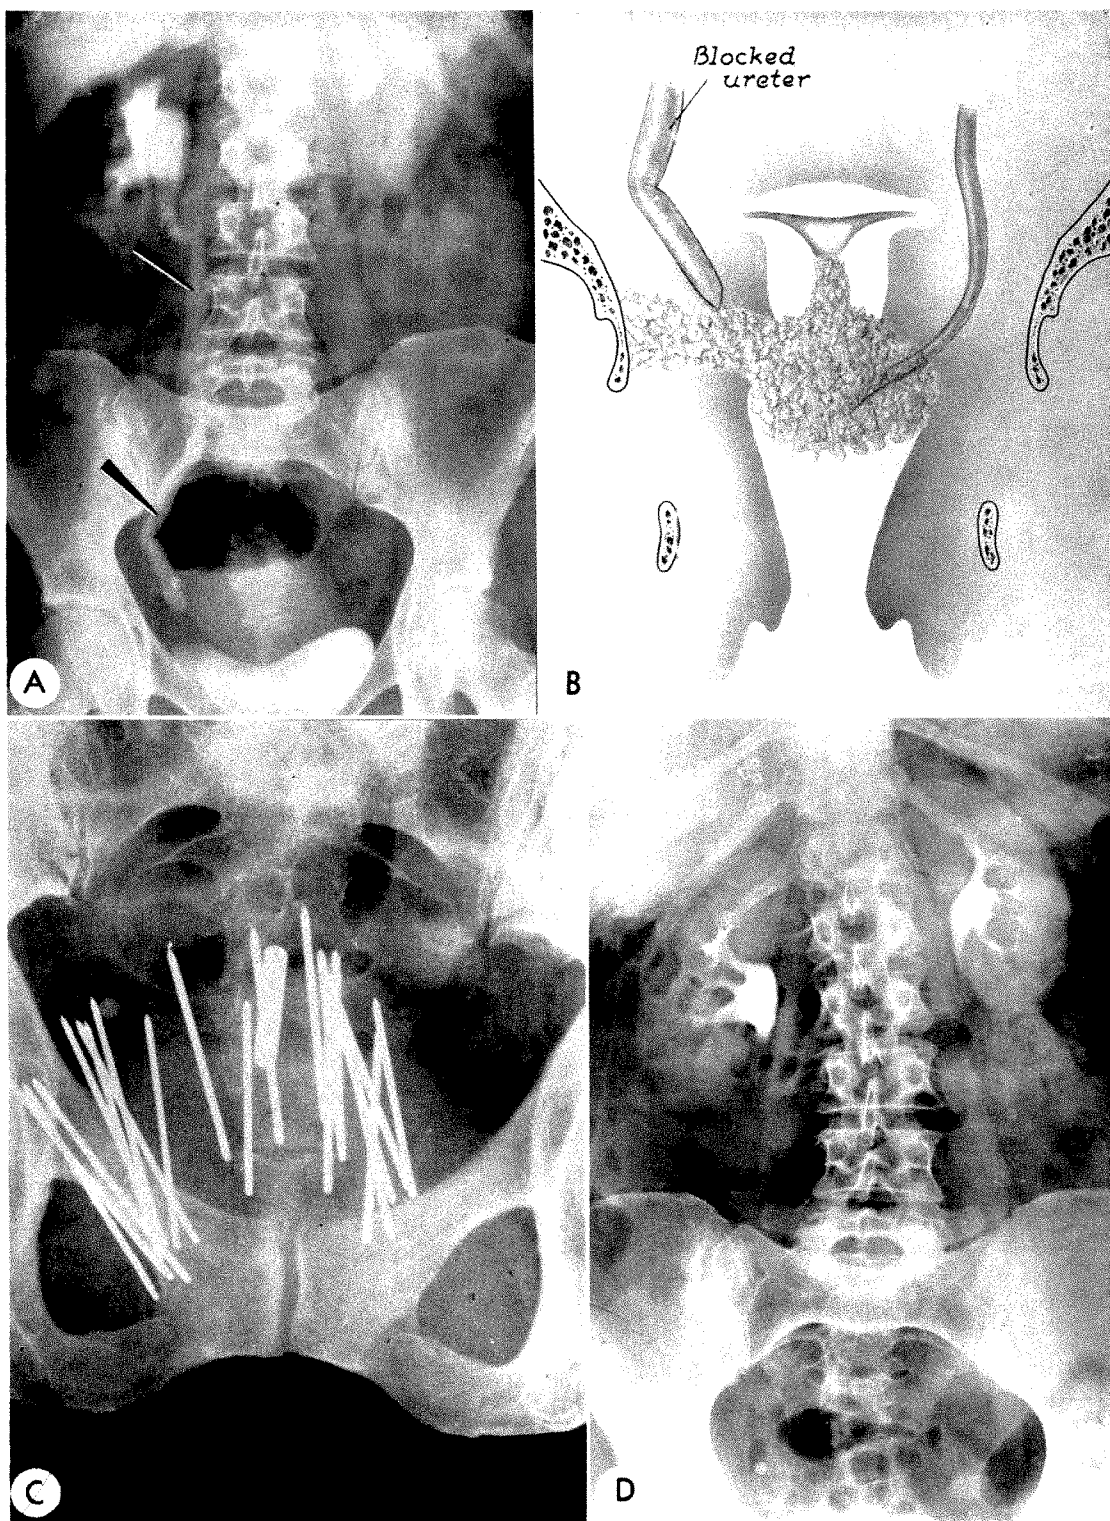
Case v. Right sided hydronephrosis from malignant invasion of the parametrium (*A* and *B*) 5 months following the implantation of low intensity radium needles in the cervix and parametrium and insertion of a low intensity cervical capsule (*C*) for 7 days and the administration of conventional roentgen therapy to the right pelvis. (*D*) The urinary tract is still normal at the end of 5 years.
